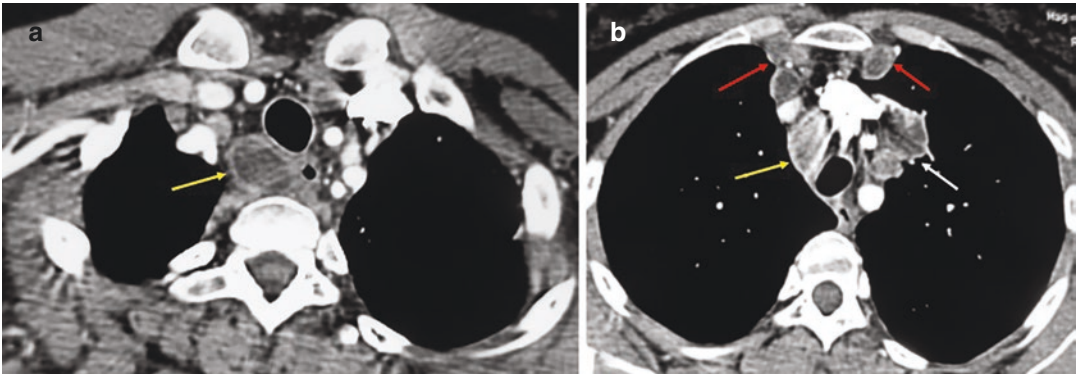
Primary tuberculosis manifesting as lymph node enlargement. (a and b) Axial contrast-enhanced CT images in soft tissue window settings show retrotracheal (yellow arrow in a), lateral tracheal (yellow arrow in b), prevascular (white arrow in b), as well as bilateral internal mammary (red arrows in b) enlarged lymph nodes, all of which have central necrotic low attenuation and peripheral rim enhancement
